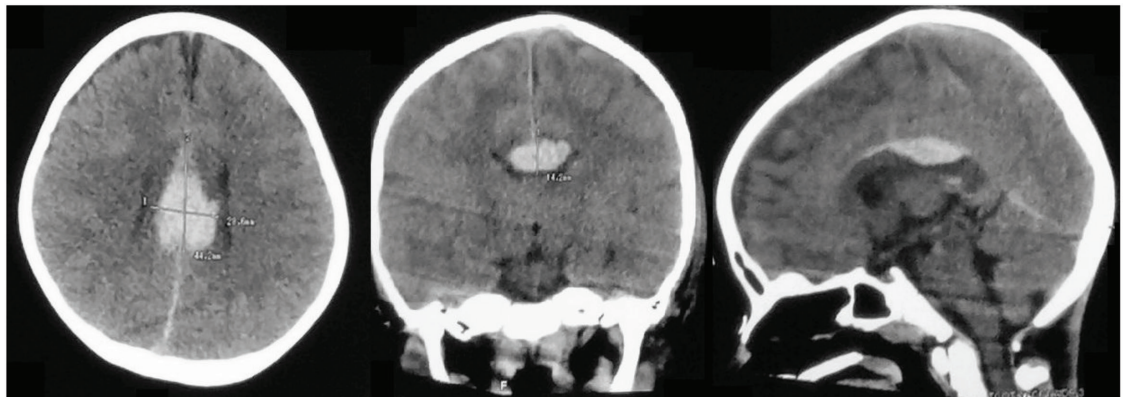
Brain CT Scan on admission showing a high signal indicating acute hemorrhage 4.4cmx-2.8cmx1.4cm involving the body of corpus callosum in axial, coronal, and sagittal view. There was also subdural hemorrhage in the interhemispheric fissure and cerebellar tentorium
